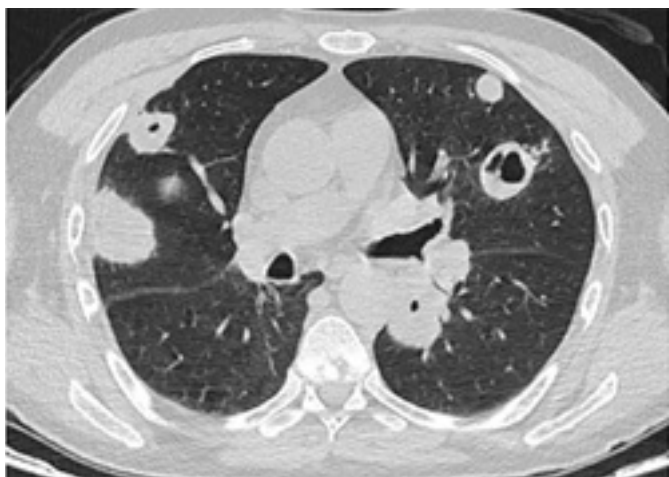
Nodules and cavities on thorax CT in granulomatosis with polyangiitis
